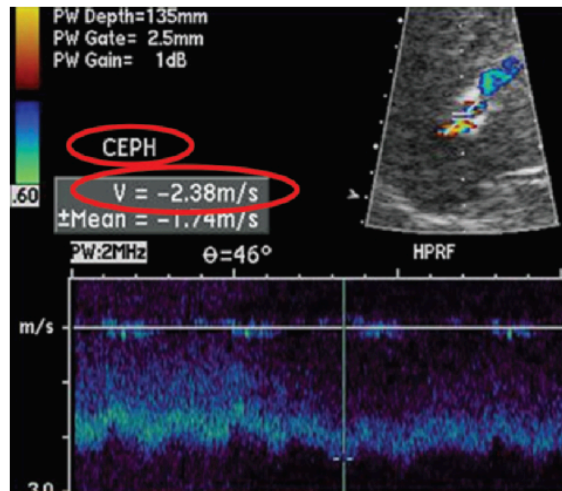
TIPS malfunction (cephalic stenosis). In a spectral Doppler US image obtained in the cephalic portion of a TIPS, the waveform shows a markedly increased flow velocity of 238 cm/sec. This location was the site of the highest flow velocity. Just upstream, in the middle portion of the TIPS, the velocity was 154 cm/sec; just downstream, in the right hepatic vein, the velocity was 126 cm/sec.
